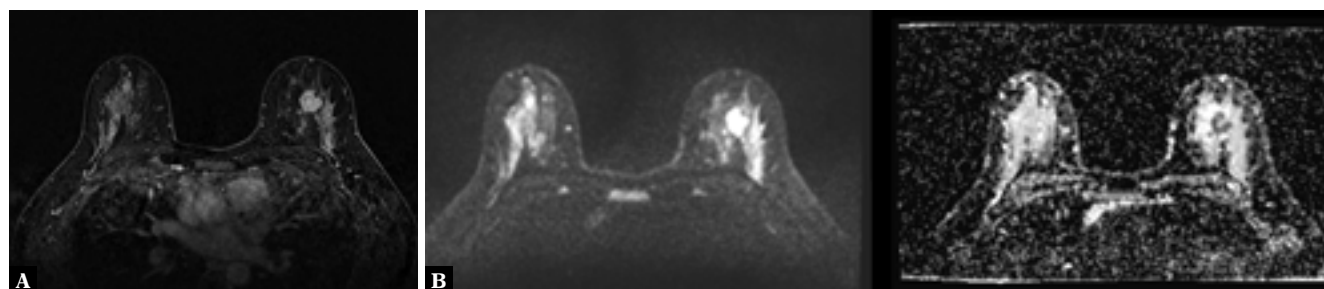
Cancer on BMRI in a patient from Fig. 1. A. Images after contrast administration. B. DWI/ADC*
